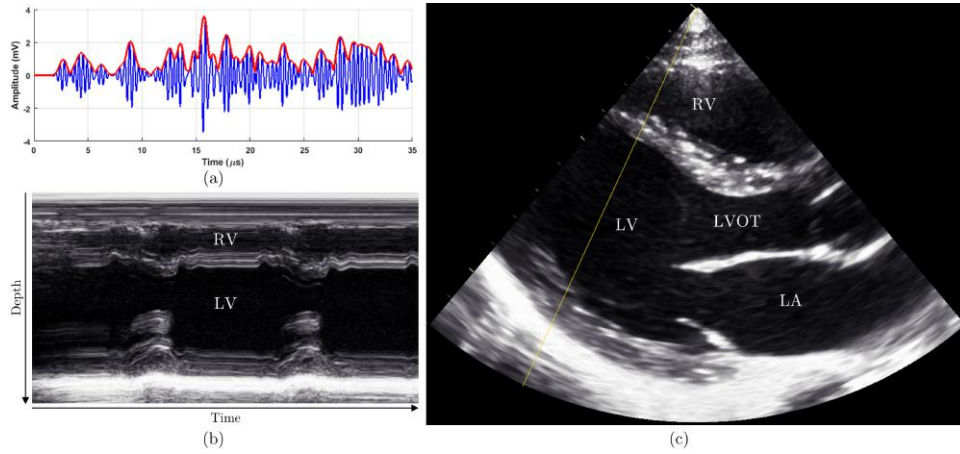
A-, M- and B-mode examples. (a) Acquired ultrasound signal (blue) and corresponding A-mode (red). (b) Parasternal long axis M-mode of the heart for assessment of cardiac wall motion during contraction. The dark regions are blood, the bright reflection is the pericardium and the gray region is between is the heart muscle itself. (c) Parasternal long axis B-mode of the heart showing the different cardiac chambers. Yellow line shows acquisition line used to produce the M-mode in (b).
